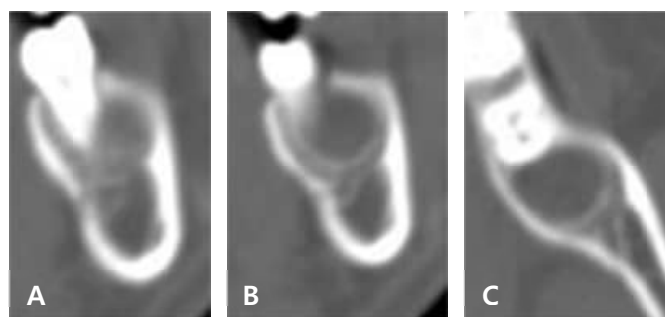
(A, B) Enhanced CT coronal view. (A) showed the cystic lesion contained distal root of #37 and buccal bone expansion. (B) showing cortical bone perforation and rim enhancement. (C) Enhanced CT axial view.
